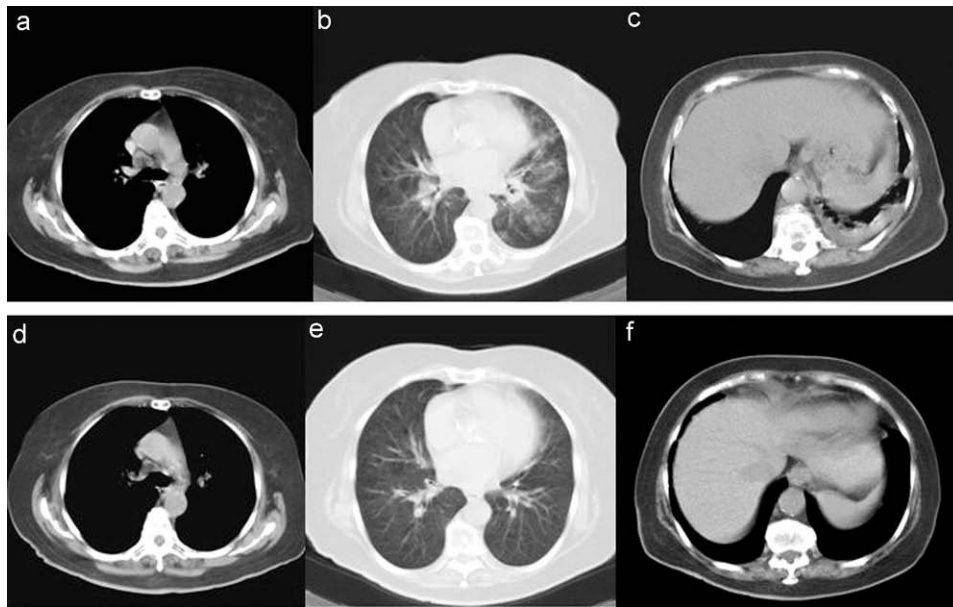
Pretreatment computed tomography scans of the chest without contrast enhancement. A. Chest CT with mediastinal window settings reveals a right paratracheal lymph node measuring 2 cm at the level of the aortic arch. B. Chest CT with pulmonary window settings shows atypical infiltrates and micronodular ground-glass opacities in the basal segments of the lower lobe and lingula of the left lung. C. Chest CT with mediastinal window settings shows left pleural effusion in the lower segments. After 1 month of follow-up. D. Chest CT scans reveal smaller mediastinal lymph nodes. E. No areas of lung infiltrate are observed. F. Pleural effusion has resolved spontaneously.
